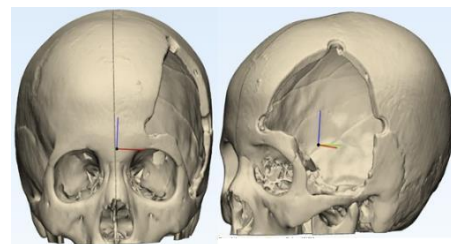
CT before Cranioplasty
